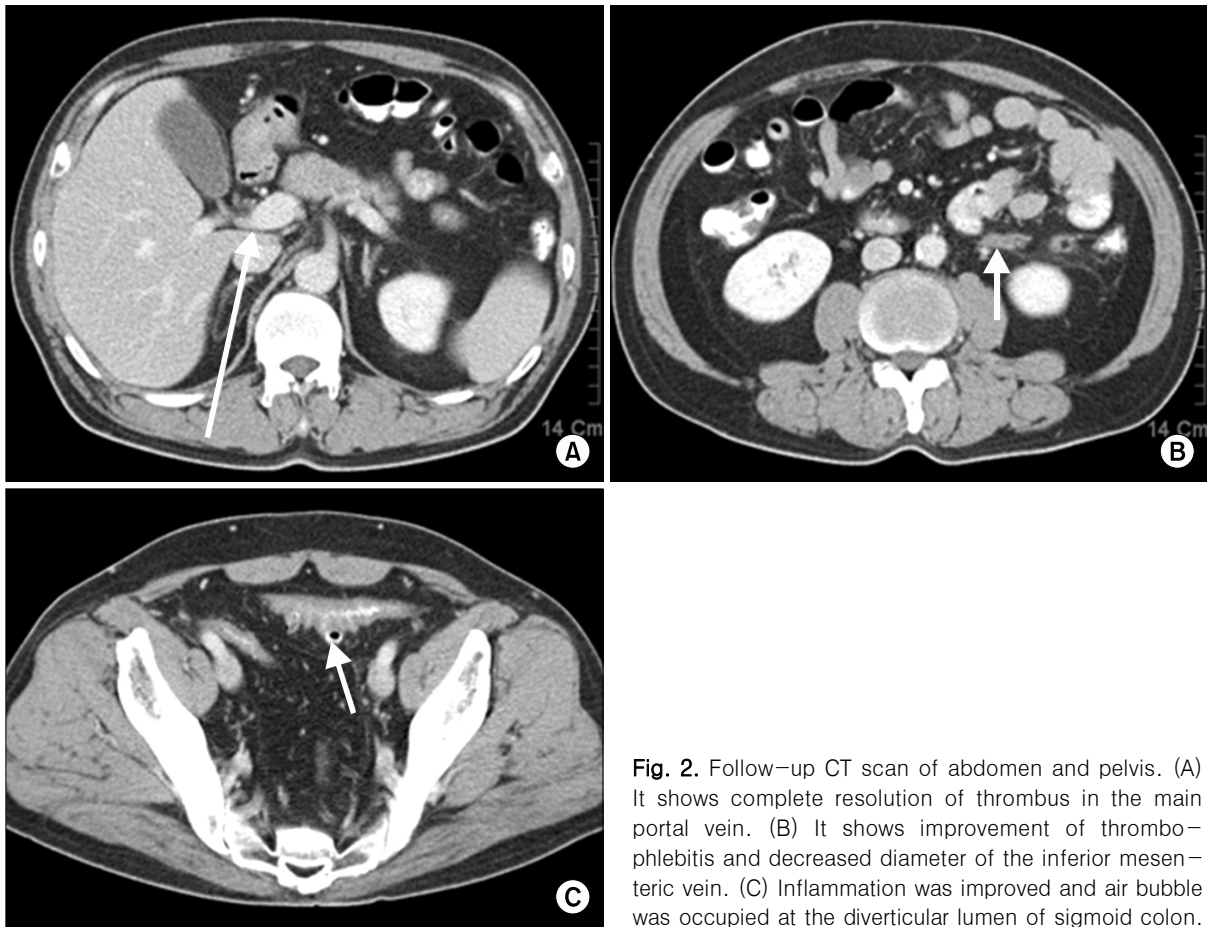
Follow-up CT scan of abdomen and pelvis. (A) It shows complete resolution of thrombus in the main portal vein. (B) It shows improvement of thrombophlebitis and decreased diameter of the inferior mesenteric vein. (C) Inflammation was improved and air bubble was occupied at the diverticular lumen of sigmoid colon.
